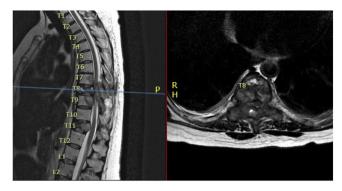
Sagittal (left) and axial (right) T2-weighted sequence of dorsolumbar MRI showing multiple metastatic lesions with lesion in D8 invading the spinal canal, vertebral body, pedicles, transverse process, and lamina.
